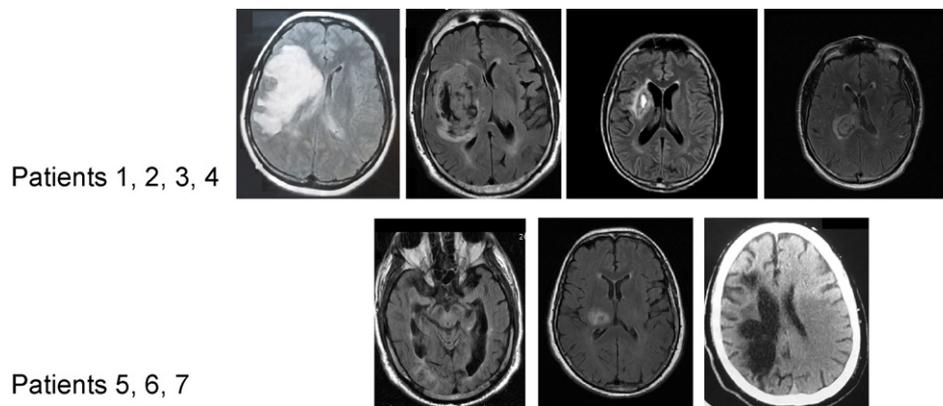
Patients' lesion sites (FLAIR coronal brain MR images). The right hemisphere is shown on the left. One scan (patient 8) was not available. Five patients had a first single unilateral stroke (ischemic $n=3$, hemorrhagic $n=2$) in the right cerebral hemisphere and three other patients had a right hematoma.
